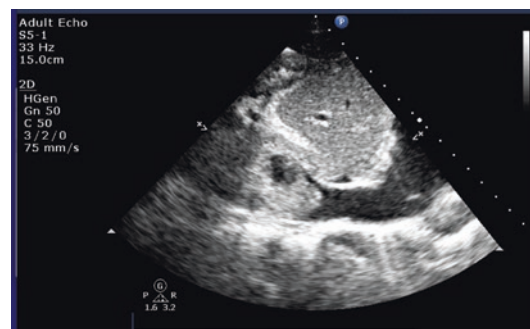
A 2D transthoracic image of renal cell carcinoma extending from the inferior vena cava into the right atrium
